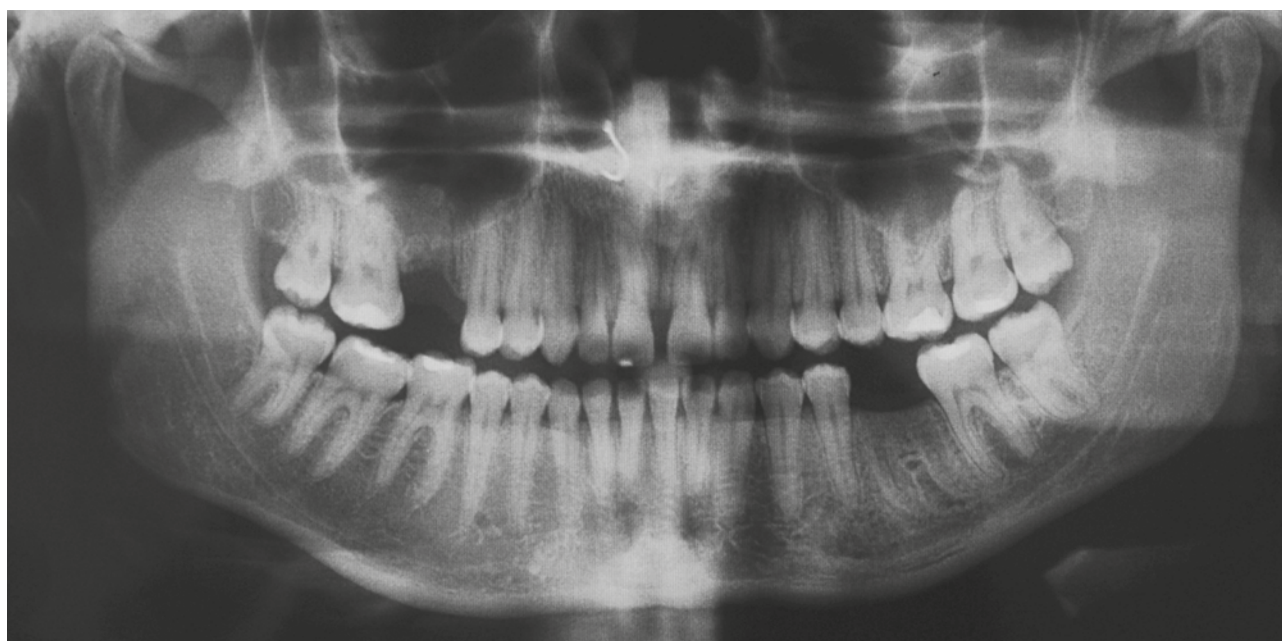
Panoramic radiograph.
